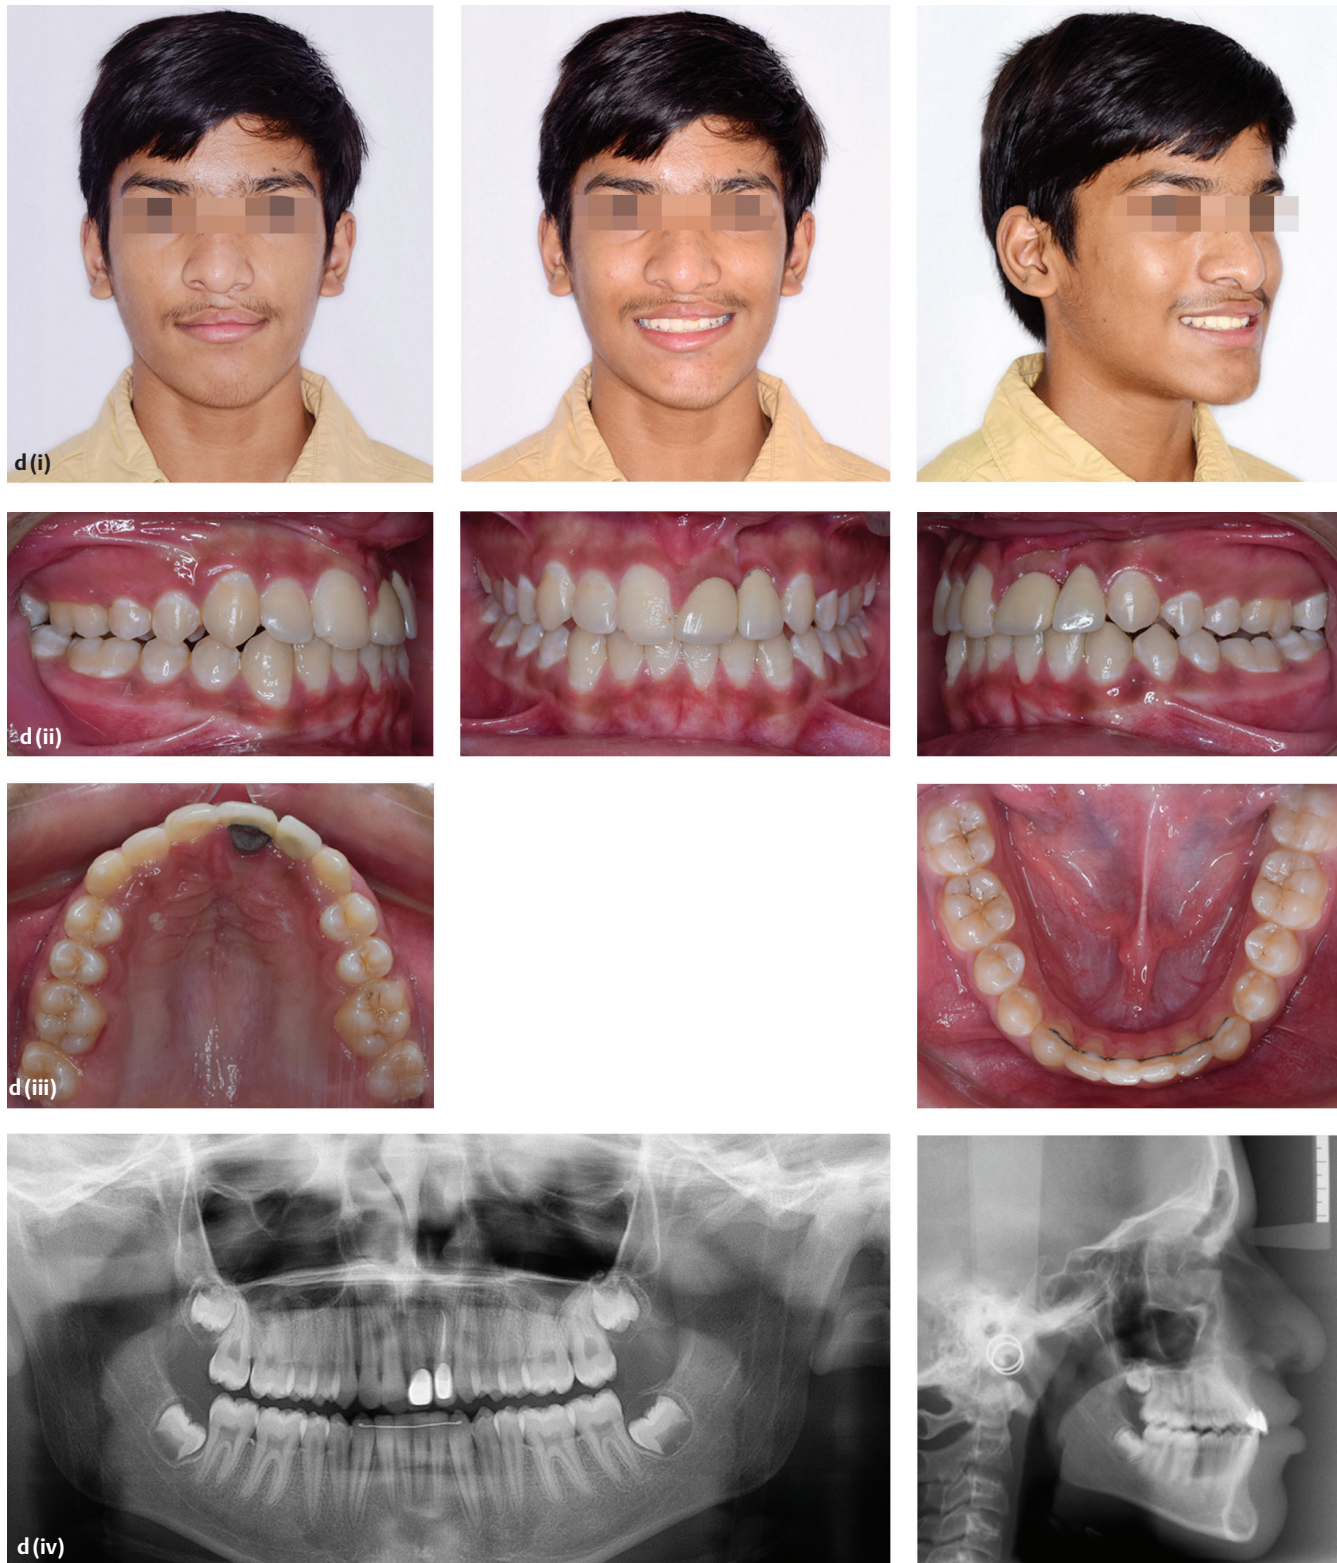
(Continued) (d) Post-treatment records: (i) Extraoral photographs show improved smile aesthetics. (ii, iii) Intraoral photographs show optimum overjet and overbite and well-aligned upper and lower arches. Note endodontically treated left lateral incisor and crowns on the left central and lateral incisor. (iv) Cephalogram and orthopantomogram (OPG) show optimum upper and lower incisor position.
